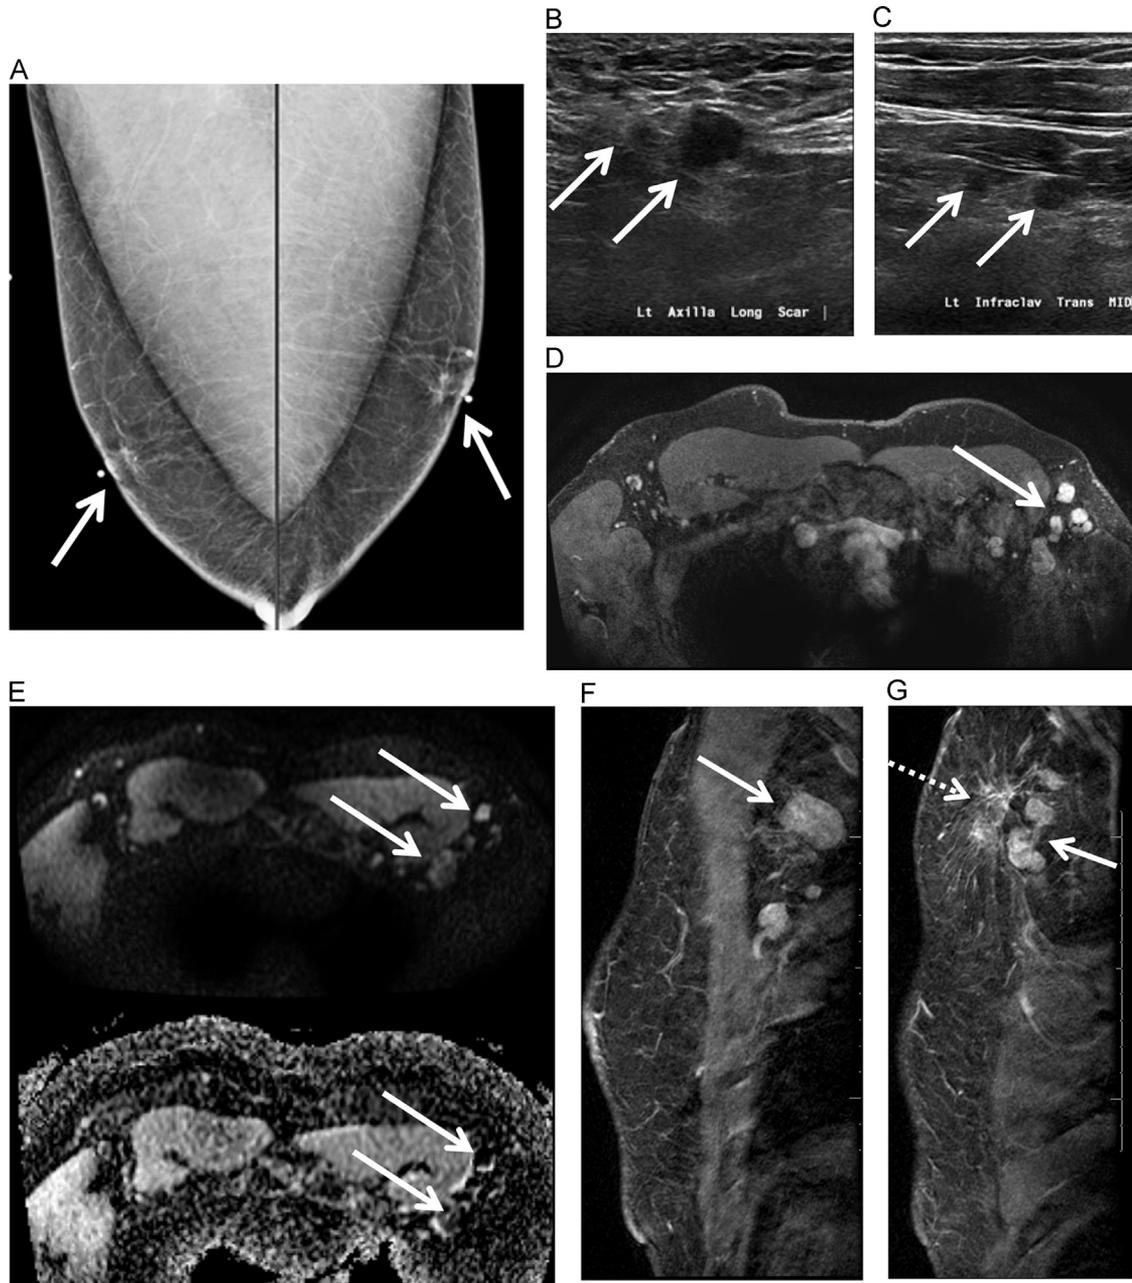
A 46-year-old male with a history of a right axillary mass, status post excision at an outside facility, yielding invasive breast carcinoma. It was unclear whether the mass was a primary lesion or a metastatic lesion. Bilateral MLO mammograms (A) demonstrate no suspicious abnormalities in the breasts. There is symmetric mild bilateral gynecomastia (arrows). US images (B and C) demonstrates multiple suspicious lymph nodes (arrows) in the left level 1 axillary and mid infraclavicular locations with irregular morphology and effacement of the fatty hila. Axial T1-weighted postcontrast image with fat suppression (D) shows multiple suspicious left level 1 axillary lymph nodes with heterogeneous enhancement and effacement of fatty hila (arrow). No other suspicious abnormality was seen to suggest another primary breast lesion. Therefore, the mass that was excised at the outside facility was likely the primary breast malignancy with associated left axillary lymphadenopathy. DWI with corresponding ADC map (E) shows restricted diffusion within the suspicious left axillary lymph nodes (arrows) seen in (B). US-guided fine needle aspiration (FNA) of the most suspicious lymph node yielded metastatic disease. Sagittal T1-weighted postcontrast images with fat suppression (F and G) demonstrate left axillary lymphadenopathy (solid arrows). Architectural distortion anterior to the lymph nodes is consistent with a post-surgical scar (dotted arrow).
